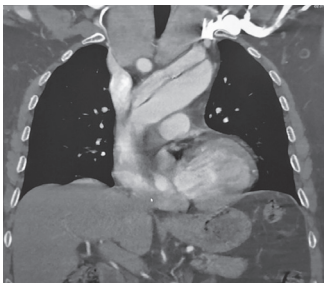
Thorax CT scan showing dissection of arcus aorta at one month in different view.
